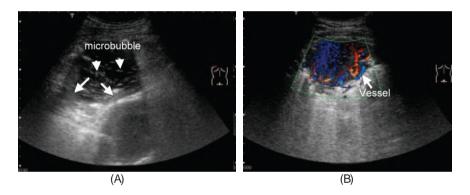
Lung abscess in chest US with Doppler. Chest US examination reveals a hypoechoic lesion with microbubble sign, which is surrounded by whole-lung parenchyma (arrows) (A). Color Doppler ultrasound can identify vessel signals in pericavitary consolidation in a lung abscess (B).
